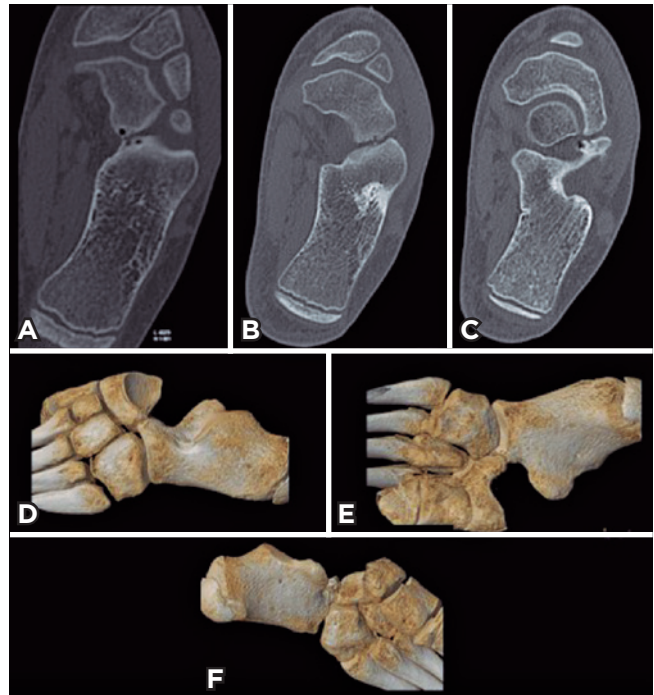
Computed tomography showing the extension of the entire tarsal coalition (left and right). A. Tarsal coalition with plantar and medial contact. B. Tarsal coalition in contact with the medial portion. C. Tarsal coalition with dorsolateral contact. 3D reconstruction images. D. Lateral view. E. Plantar view. F. Medial view.
